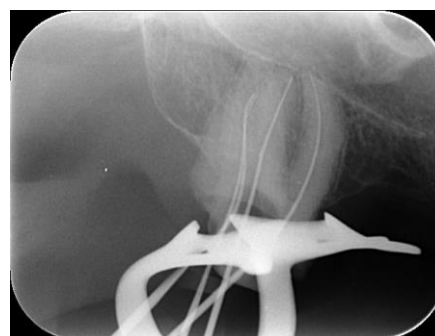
The working length radiography
